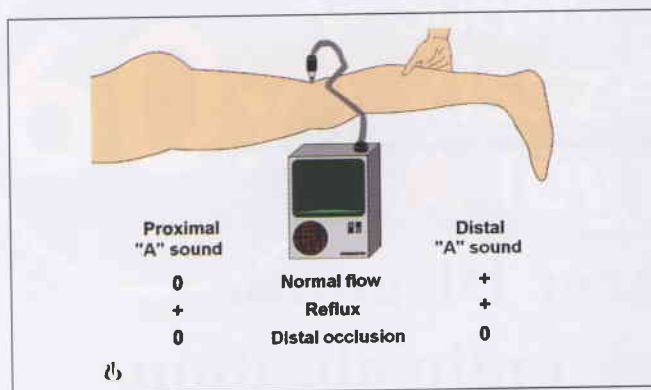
Manual squeeze (calf and thigh) test with CW Doppler testing "A"ugmentation sound of popliteal vein.
